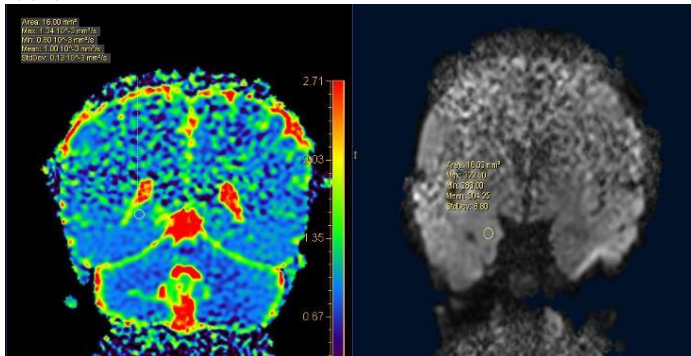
ADC image of posterior section of right hippocampus Figure 7: Diffusion MR image of right amygdala
